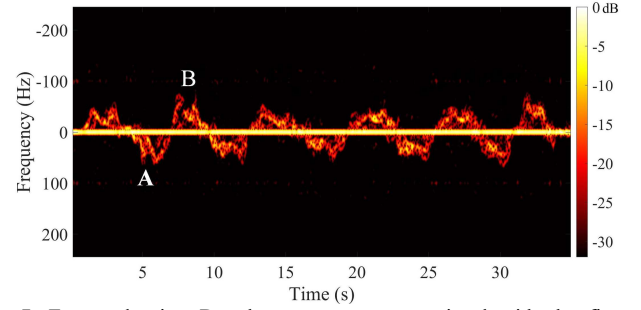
Extracted micro-Doppler spectrogram associated with the five sit-ups done by P1.
